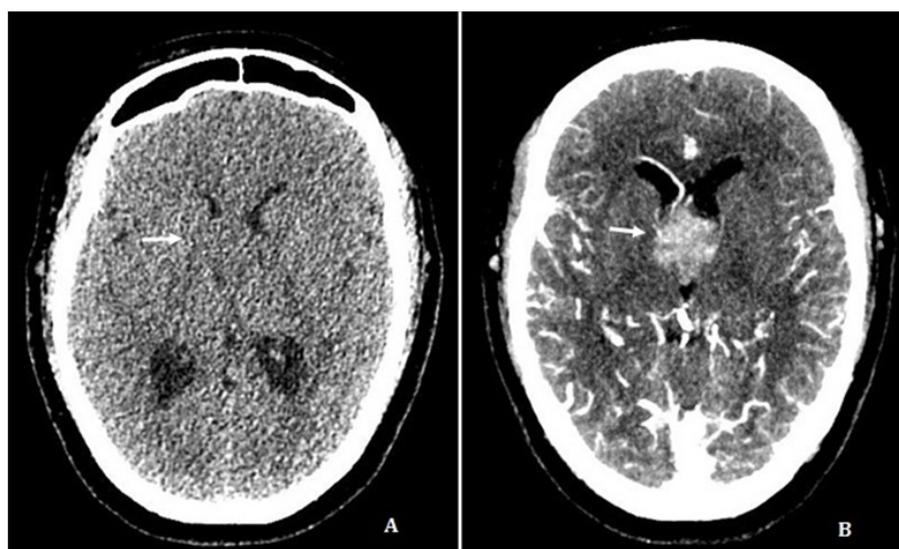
Axial CT scan without intravenous contrast (A) and Maximum Intensity Projection (MIP) reconstruction with intravenous contrast (B) showing an enhancing round mass inside the third ventricle lumen (arrow).
